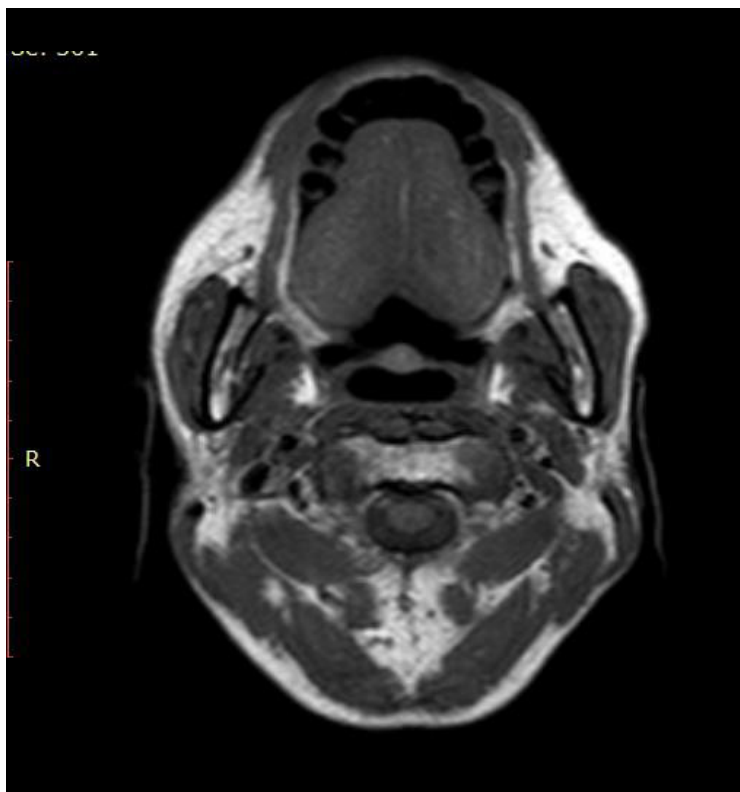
MRI shows a significant parotid gland atrophy.
